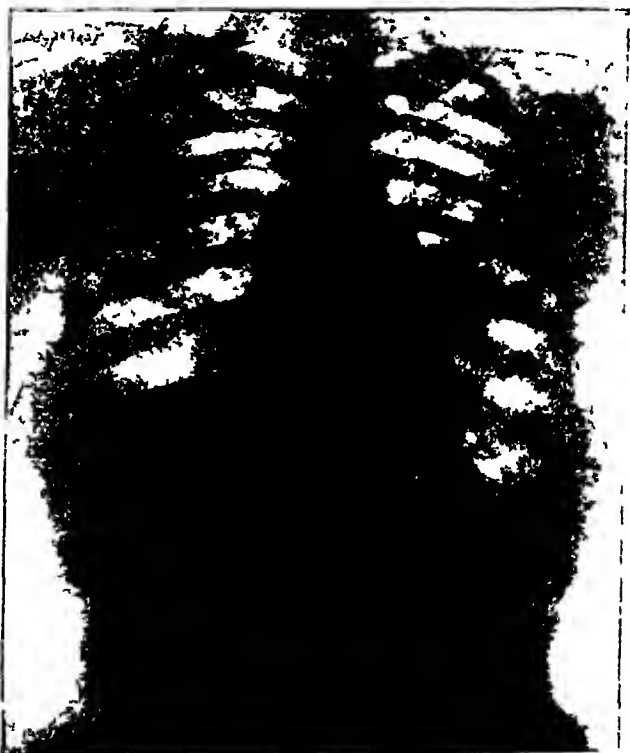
Case III x-Ray taken September 19, 1924—sixteen days after antiluetic therapy had been instituted The pathologic shadows are beginning to clear
